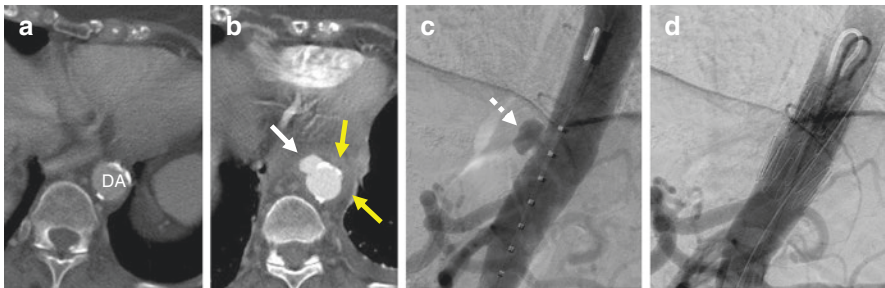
Penetrating atherosclerotic ulcer. Ten months after a CT scan demonstrated a normal caliber, atherosclerotic descending thoracic aorta (a), this patient presented with acute back pain and evidence at repeat CT (b) of a new focal aortic ulceration at the site of atheroma consistent with a PAU (white arrow). There is circumferential high-density thickening of the wall (yellow arrows) likely due to a component of short-segment IMH, and the aortic wall is indistinct. Images (c) and (d) demonstrate the lesion at angiography (white arrow) before and after stenting. Notice on (c) the characteristic mushroom-like outpouching. DA Descending aorta
